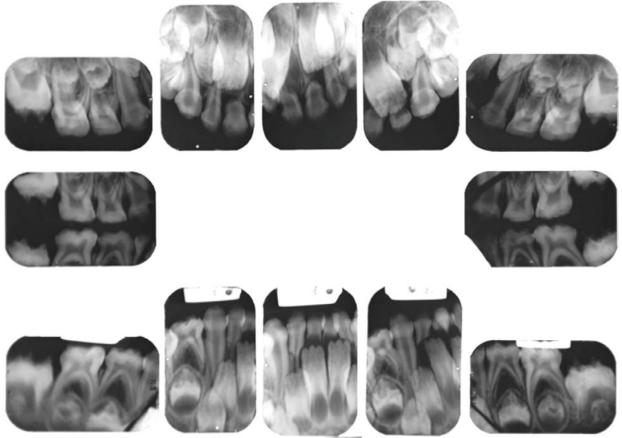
Child full mouth survey showing hypoplastic amelogenesis imperfecta, generalized pattern. Note the loss of enamel and flattened occlusal surfaces in the primary dentition. A thin layer of enamel can be seen radiographically.
